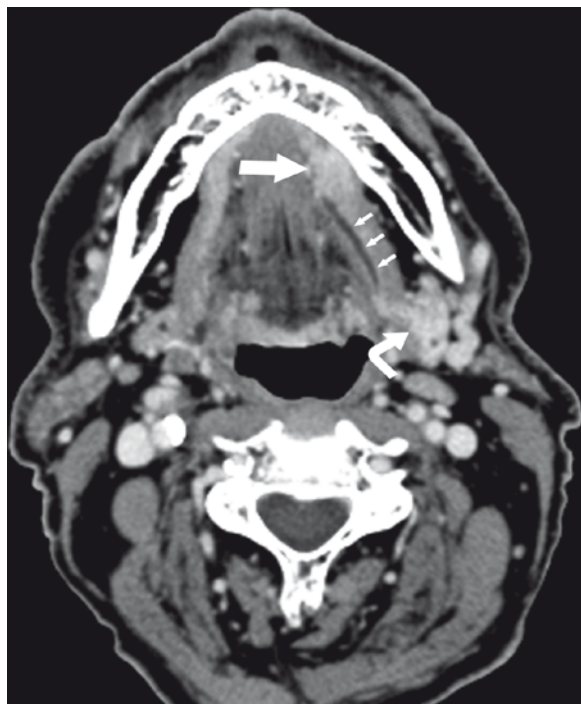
Floor of mouth carcinoma, clinically N1. Axial CT image shows the enhancing floor of mouth primary (*large straight arrow*). Note the obstructed, dilated submandibular duct (*small arrows*) and an enlarged, enhancing left submandibular gland (*curved arrow*). This gland was palpable and presumed to be a nodal metastasis. In this case, imaging served to downstage the neck. There were no nodal metastases detectable elsewhere in the neck
